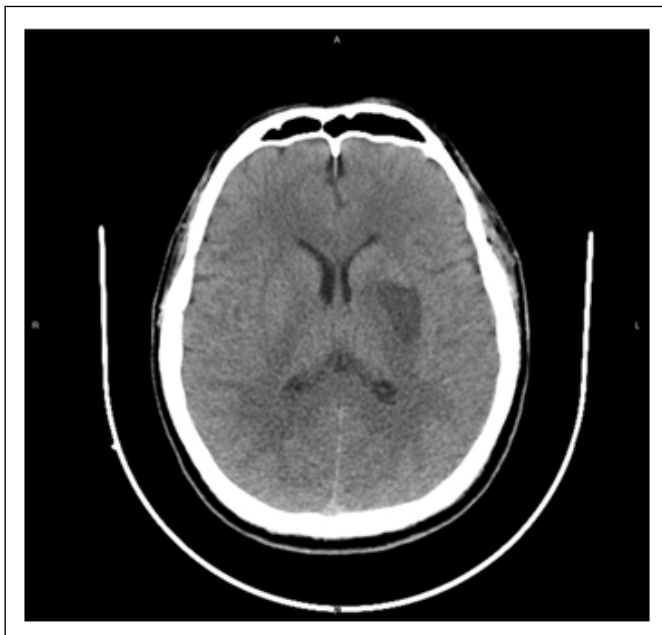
Non-contrast routine brain CT scan examination 3 days after hospitalization.
